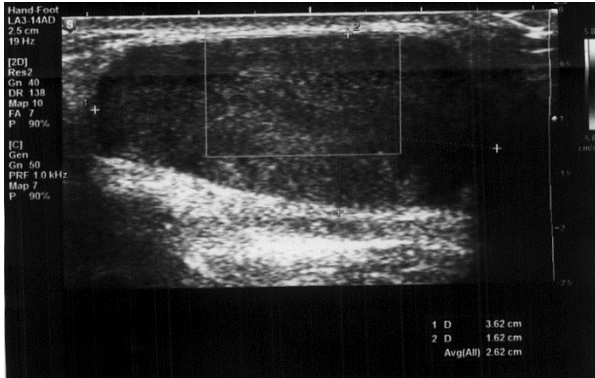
Ultrasound image of the left ankle demonstrating the hypochoic pattern in the mass
